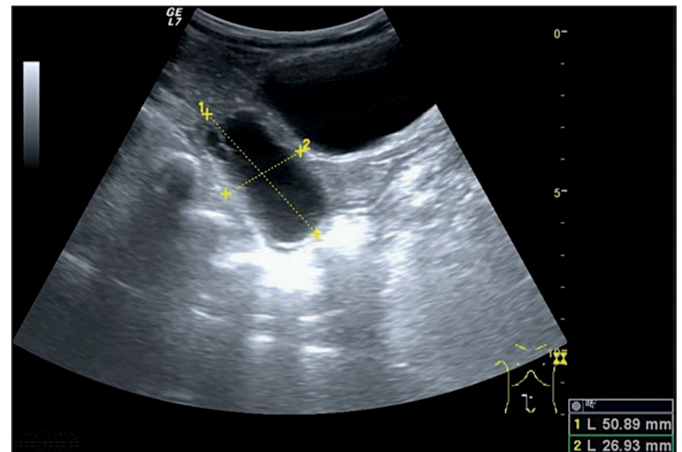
Ultrasound showing cystic lesion in the right ovary
